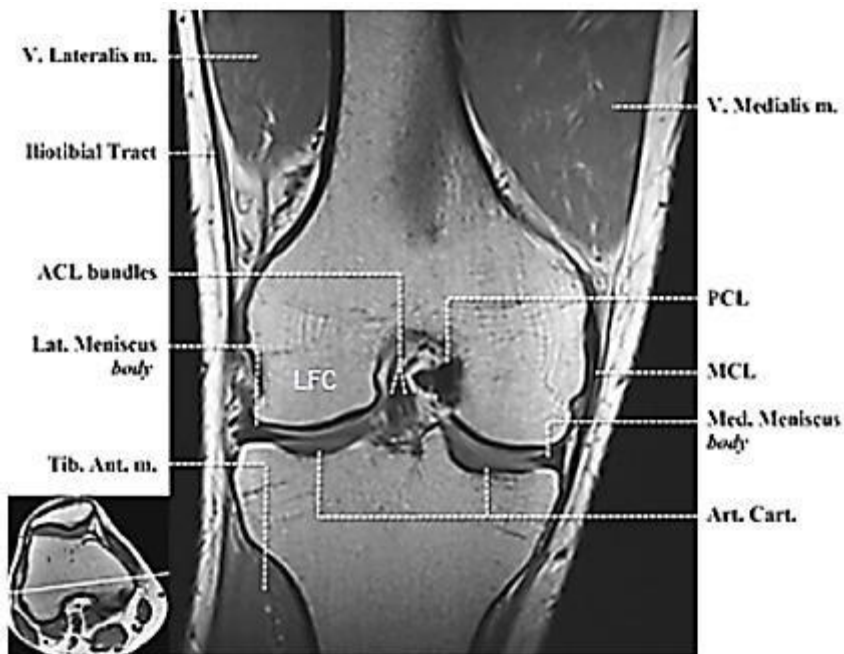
Coronal T1-weighted image at mid coronal plane showing normal ACL: The mid and distal ACL in the intercondylar fossa. The fibres are running superiorly and laterally within the intercondylar fossa from tibial attachment to the lateral femoral condyle (LFC). The more medial portion is the AM bundle while the lateral portion is the PL bundle. ACL: anterior cruciate ligament; MCL, medial collateral ligament; PCL, posterior cruciate ligament.^[45]
